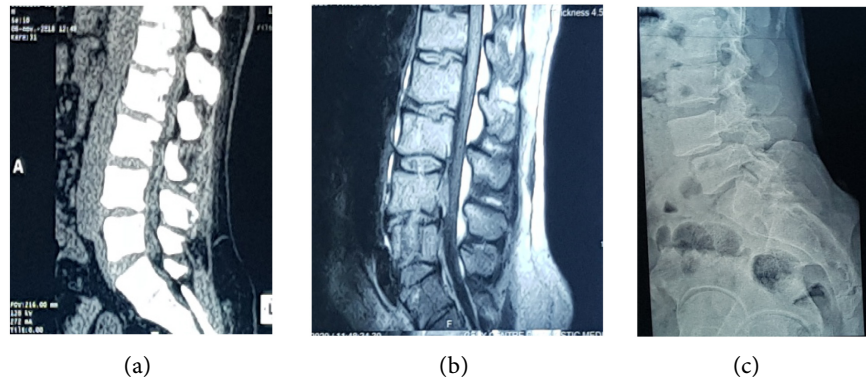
Dynamic profile earthworm radiography showing the importance of spondylolisthesis (Meyering 3 Grade).
